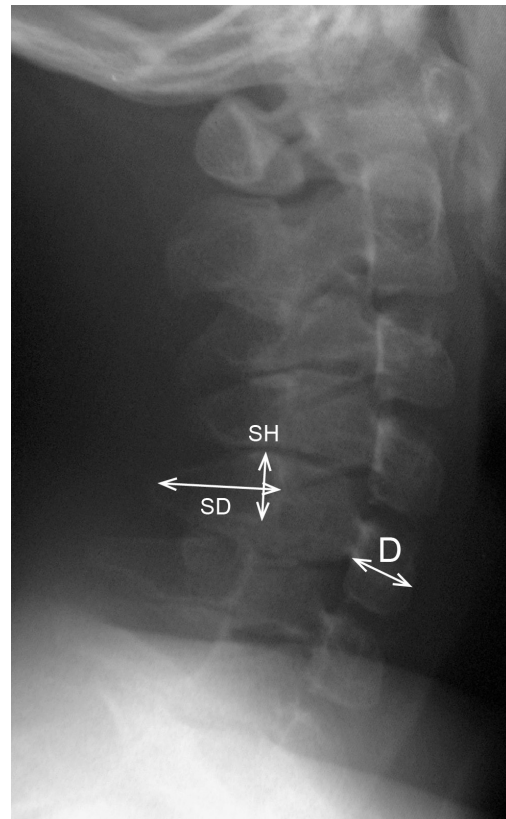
A lateral radiograph of the cervical spine of Patient 16 at the age of eight years showing enlarged spinous process of the C5 vertebra. The (SH+SD)/D ratio and the corresponding SD value is 2.8 and 7.9, respectively.
